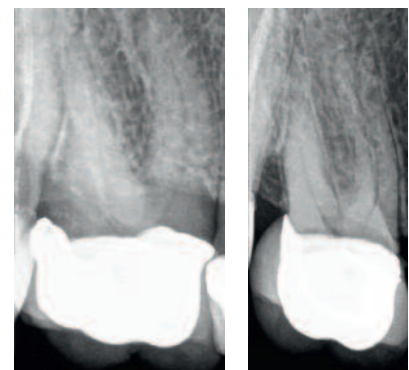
Radiographic examination six months post-treatment. No signs of periapical pathology could be observed
